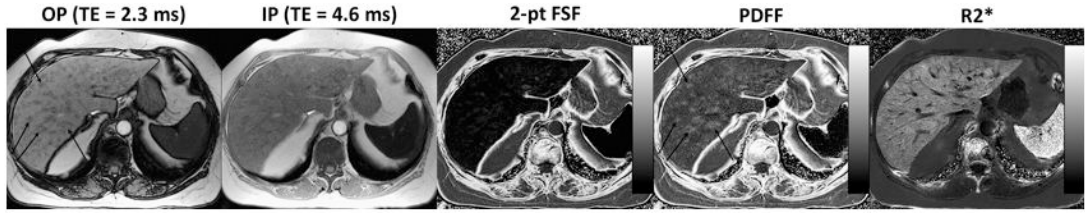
Simultaneous measurement of fat-fraction and R_2^* using the Bydder method. Multiple unusual hypodense lesions were identified at CT (not shown), concerning for metastatic disease. Conventional IOP imaging reveals multiple hypointense nodules, best seen on OP images (left) corresponding to the hypodense nodules seen on CT. Fat signal fraction (FSF) calculated with 2-point IOP imaging (equation 2) shows no evidence of liver fat, because of T_2^* shortening. PDFF and R_2^* maps measured with the Bydder method show diffuse fatty liver with nodular areas of focal fat, as well as elevated R_2^* (shortened T_2^*) in both the liver and spleen suggestive of hemosiderosis.
